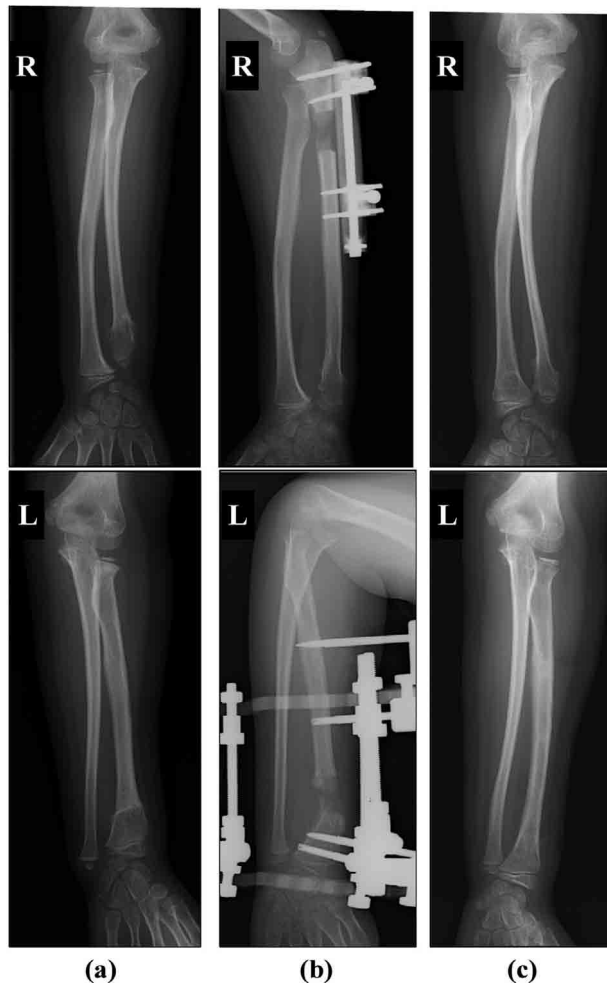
Case 2 : (a) Radiographs of the forearms of an 8-year-old girl, showing hypoplastic left distal radius and right distal ulna with large distal exostoses, before osteotomy. (b) Radiographs showing distraction osteogenesis of the right ulna with Orthofix and the left radius with Ilizarov frame immediately after the completion of the lengthening. (c) At 358 days after osteotomy, radiographs showed no radial head subluxation and the angular deformity of the right radius was corrected.
